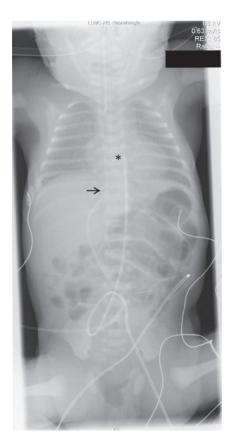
Anteroposterior thoraco-abdominal X-ray to determine position of umbilical catheters. The tip of the umbilical venous catheter (arrow) projects in between 9th and 10th thoracic vertebra, outside the cardiothymic silhouette, just below the diaphragm. The tip of the umbilical artery catheter (asterisk) projects just above 7th thoracic vertebra. Both catheters were accepted for use.
